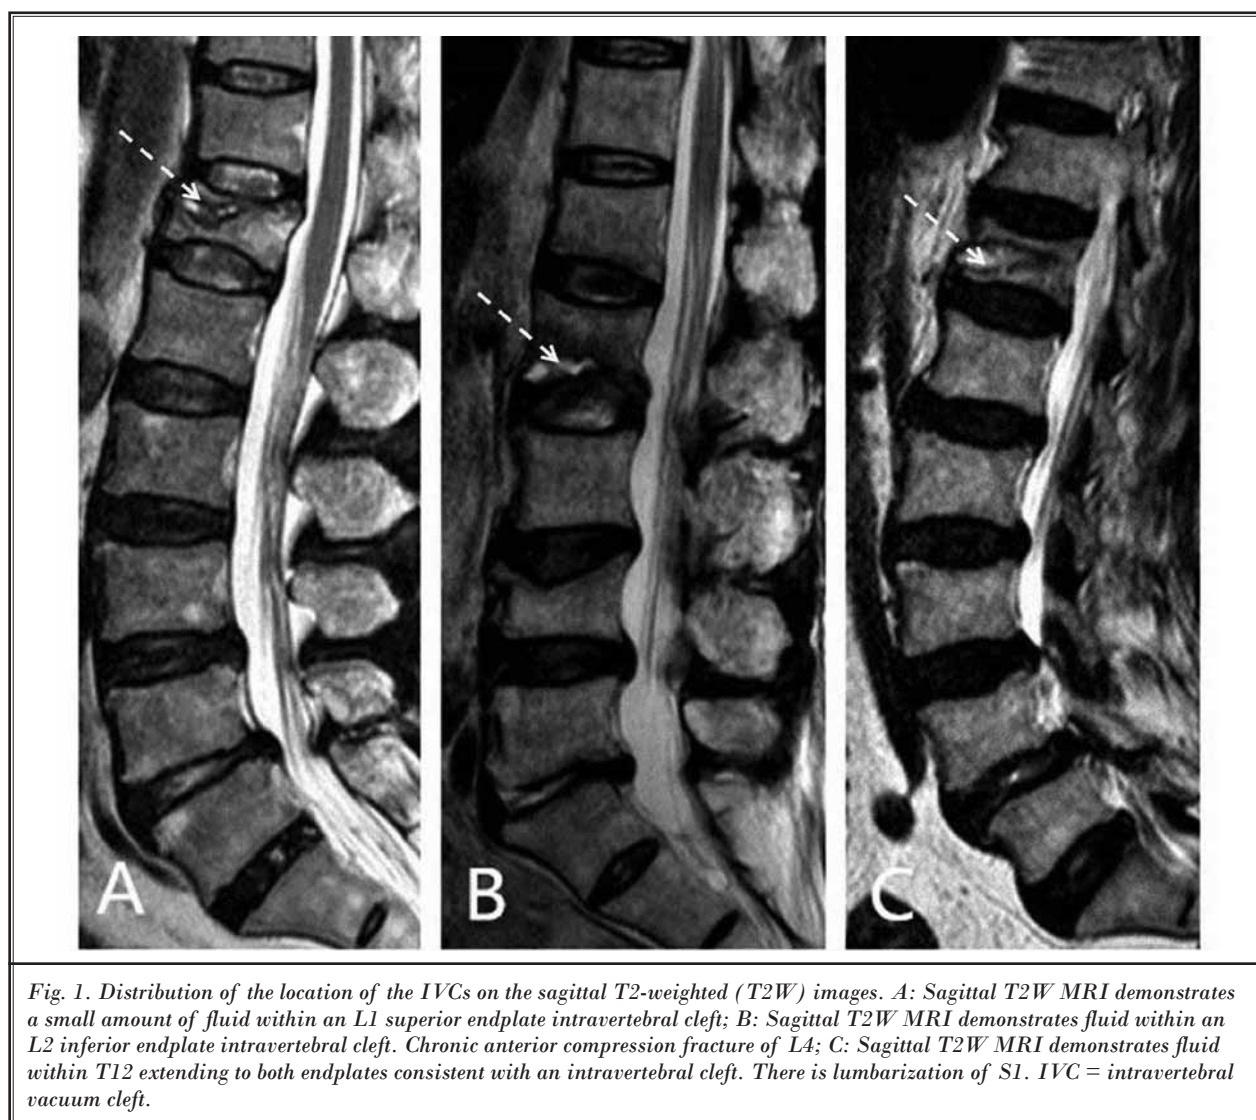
Distribution of the location of the IVCs on the sagittal T2-weighted (T2W) images. A: Sagittal T2W MRI demonstrates a small amount of fluid within an L1 superior endplate intravertebral cleft; B: Sagittal T2W MRI demonstrates fluid within an L2 inferior endplate intravertebral cleft. Chronic anterior compression fracture of L4; C: Sagittal T2W MRI demonstrates fluid within T12 extending to both endplates consistent with an intravertebral cleft. There is lumbarization of S1. IVC = intravertebral vacuum cleft.
